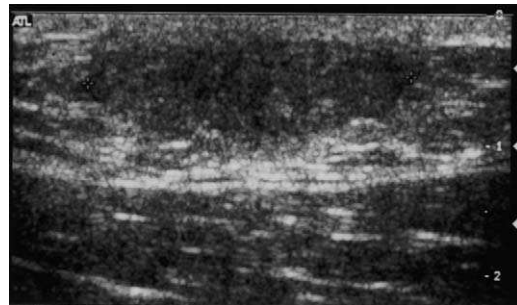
Gynecomastia. Calipers mark an area of asymmetric breast tissue in a man who presented with a lump and breast pain. Sonographic findings, interpreted in conjunction with mammographic findings (not shown), led to the diagnosis of gynecomastia.
